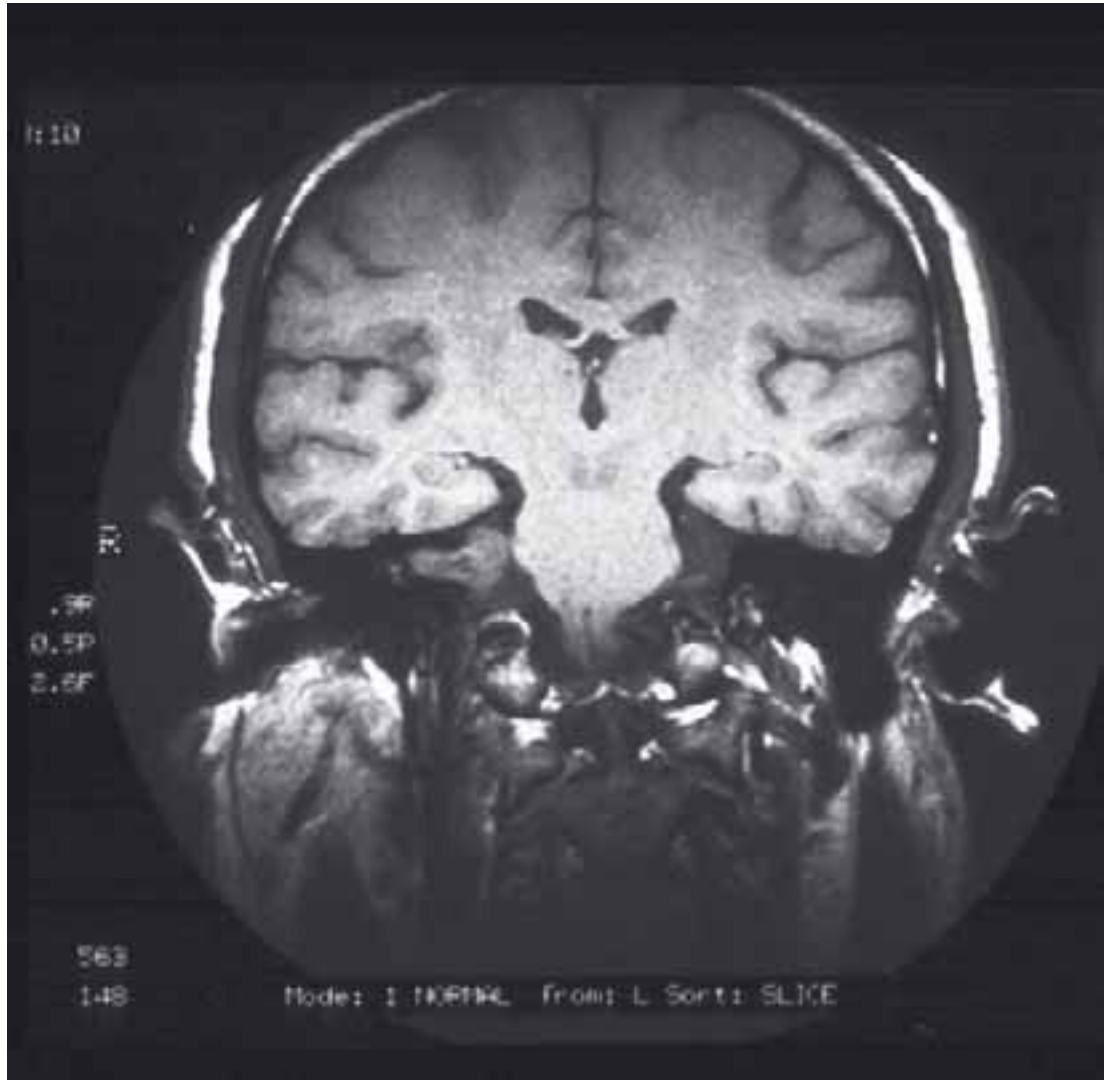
MRI scan demonstrating right vestibular schwannoma.
